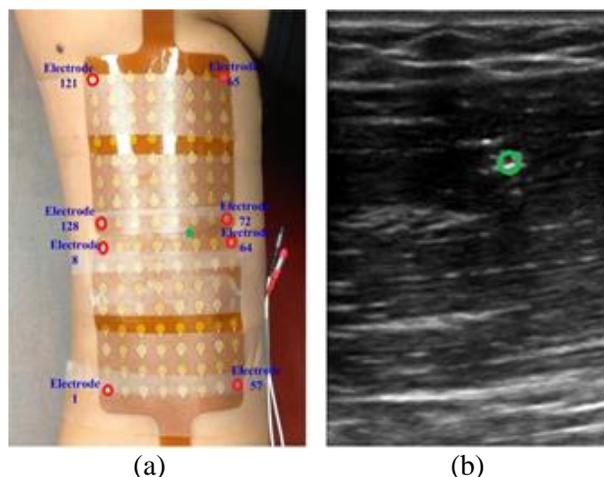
shows (a) position of 128-channel surface EMG recording electrodes (2 flexible 8×8 arrays with the electrode diameter of 5 mm, and the center-to-center electrode distance of 8.5 mm) and wire electrode (green star) over the subject's right upper arm, and (b) location of the inserted wire electrode (green circle) in the ultrasound image of the upper arm. Note that the wire electrode is inserted at the midpoint of the 48th and 96th surface EMG electrodes.
